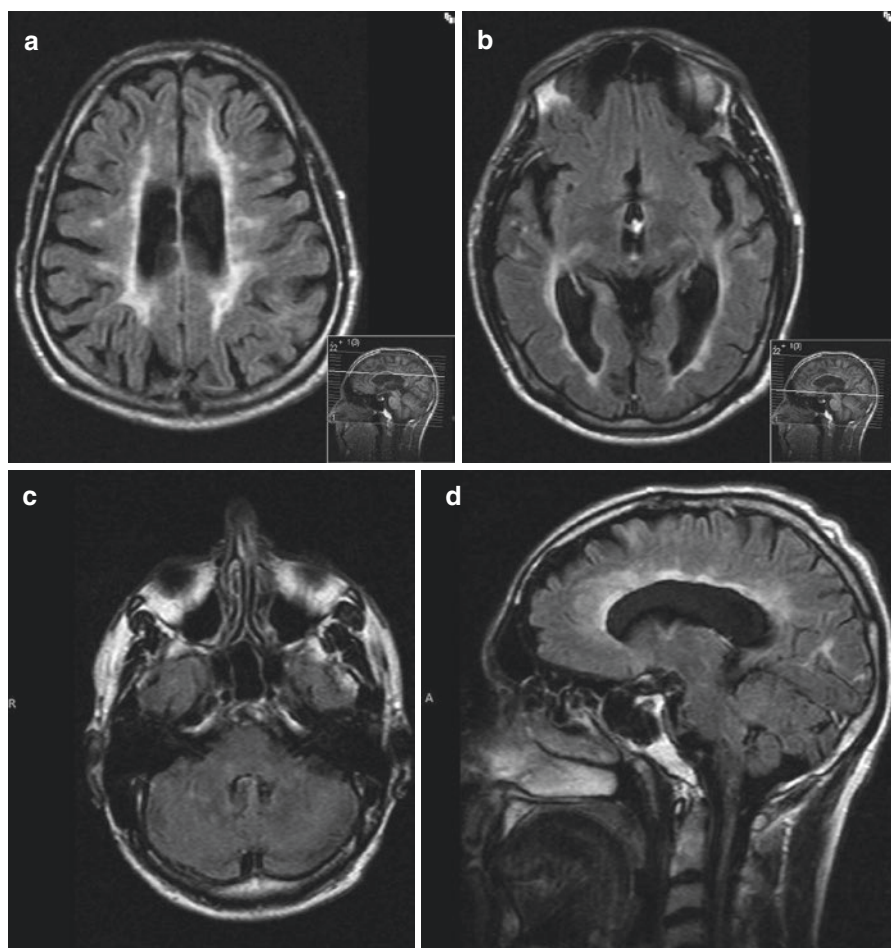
FLAIR sequence (a–c) axial and (d) sagittal MRI showing numerous white matter lesions in a periventricular pattern within the brain and brain stem typical of that seen in multiple sclerosis. There are several lesions within the corpus callosum. Note the lesion seen medially at the pontomedullary junction (d)
